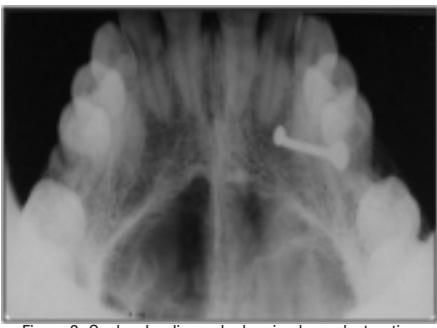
Occlusal radiograph showing bone destruction
